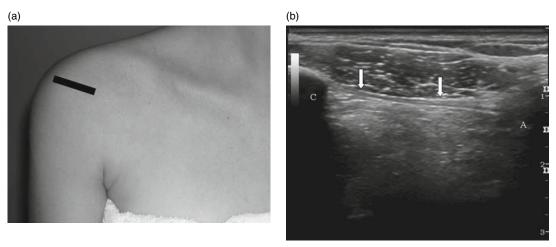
Coracoacromial ligament (arrow): (a) transducer position and (b) corresponding ultrasound image. C, coracoid; A, acromion.
